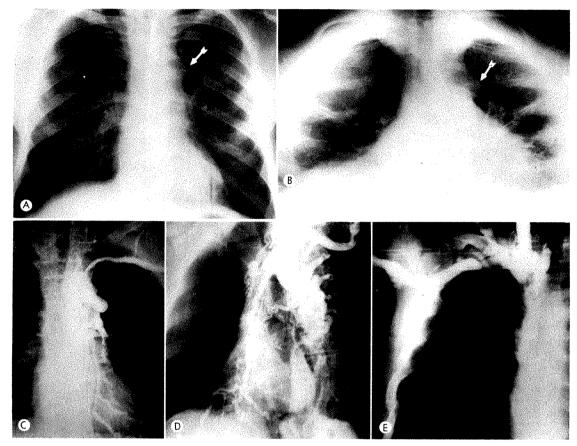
Case I. (A) Frontal teleroentgenogram showing widening of the right superior mediastinum with a small left mediastinal mass (arrow). (B) Lordotic frontal roentgenogram more clearly reveals the left mediastinal shadow (arrow). (C) Frontal angiocardiogram (left arm injection) demonstrates that the dilated tortuous hemiazygos venous channels are responsible for the left mediastinal mass. (D) Left anterior oblique roentgenogram showing the tremendously dilated hemiazygos system finding its way to the inferior vena cava. (E) Frontal angiocardiogram (right arm injection) showing the superior vena caval occlusion and that the widened right mediastinal shadow is due to the dilated right innominate vein.
